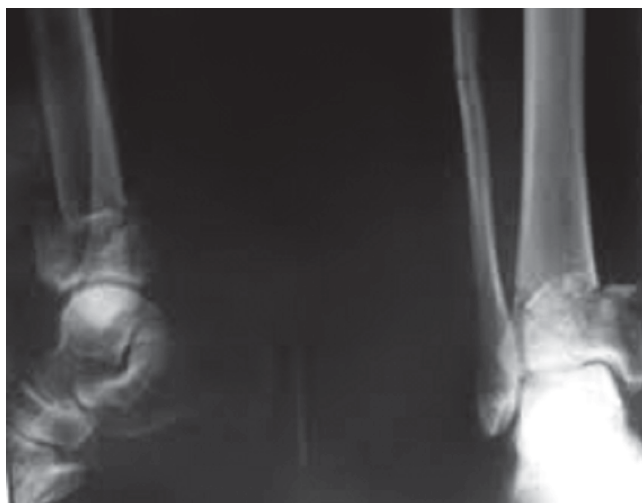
Radiographs views after the surgery (A), and after 1 month (B).
